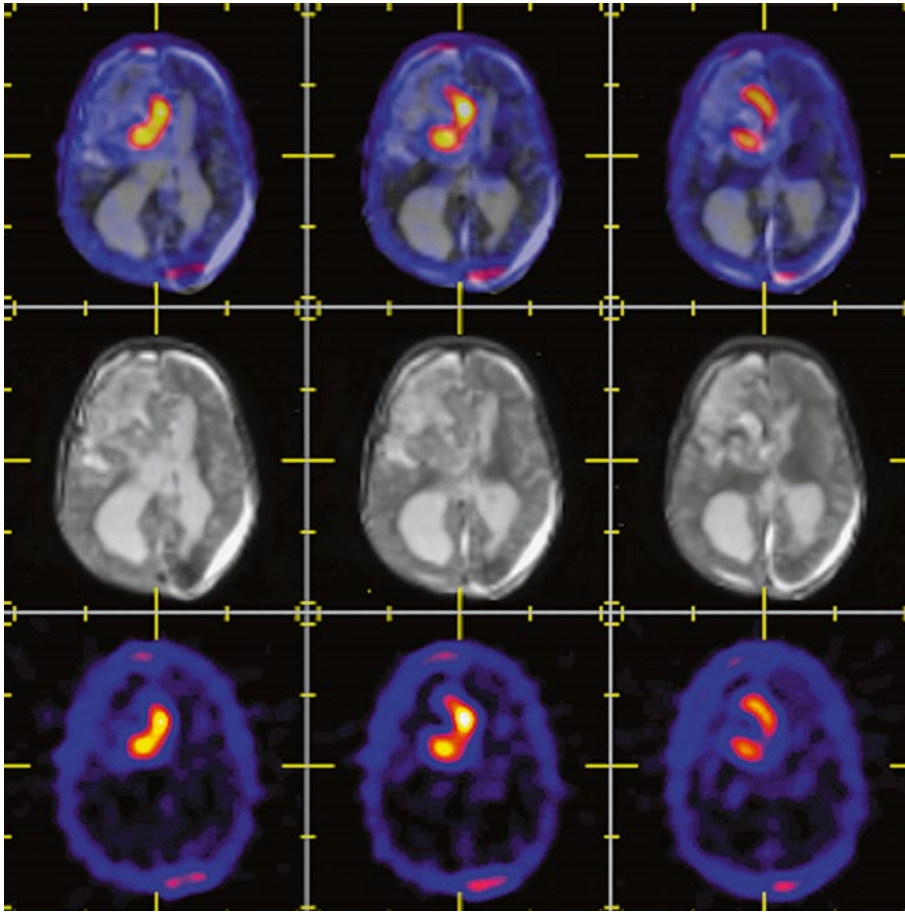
Metastatic neuroblastoma in the brain. *Top row:* MRI/ ^{201}Tl fusion showing anatomic–functional relations. *Middle row:* selected MRI slices depicting extensive abnormality in the right frontoparietal region.
